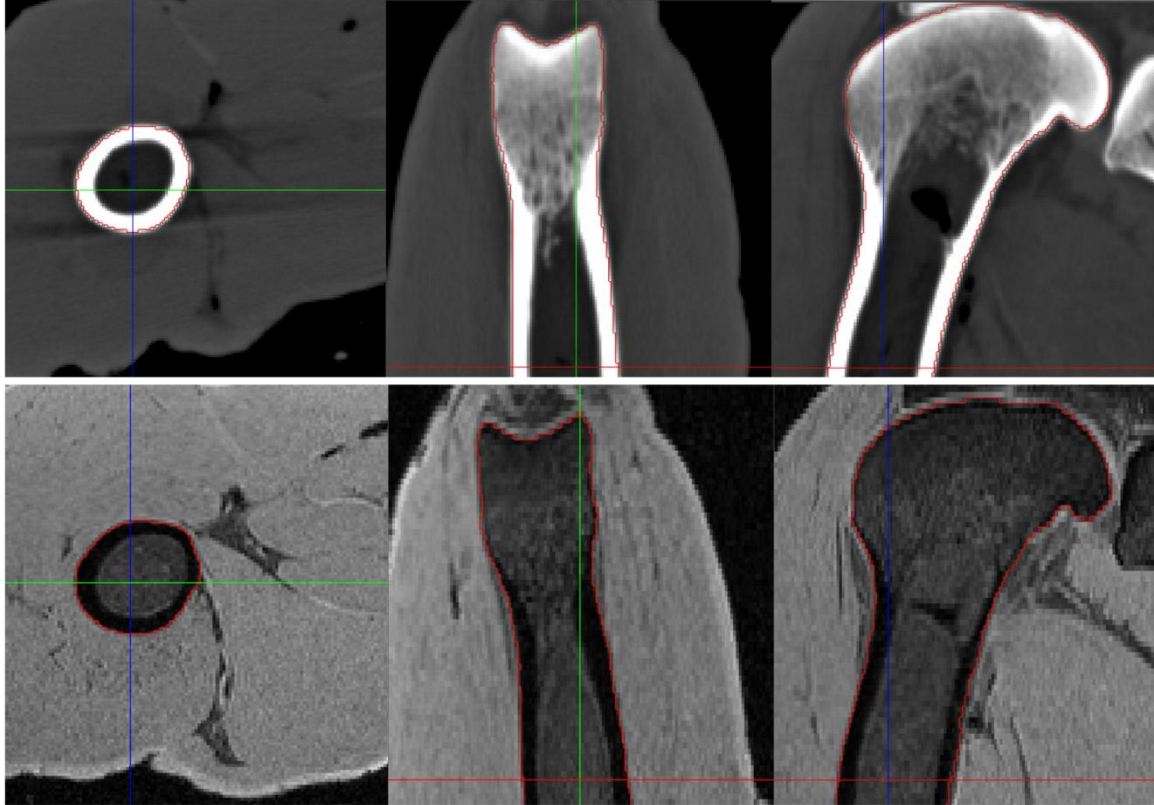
Three orthogonal views (axial, coronal and sagittal) of thresholded bone from CT (above) and MRI (below) (only the proximal half of the bone is shown in coronal and sagittal views)
